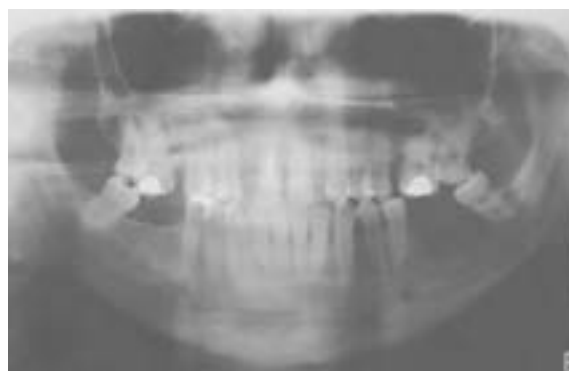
Initial panoramic radiograph showing radiolucent area with undefined borders.
